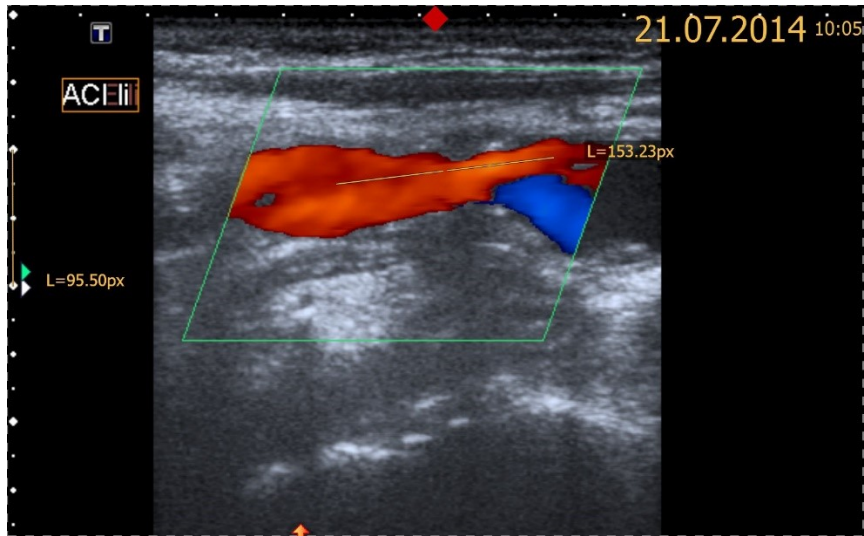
Ultrasound examination (patient 81) showing large plaque on the left side causing an ICAD of 20-40%, 16 mm long
